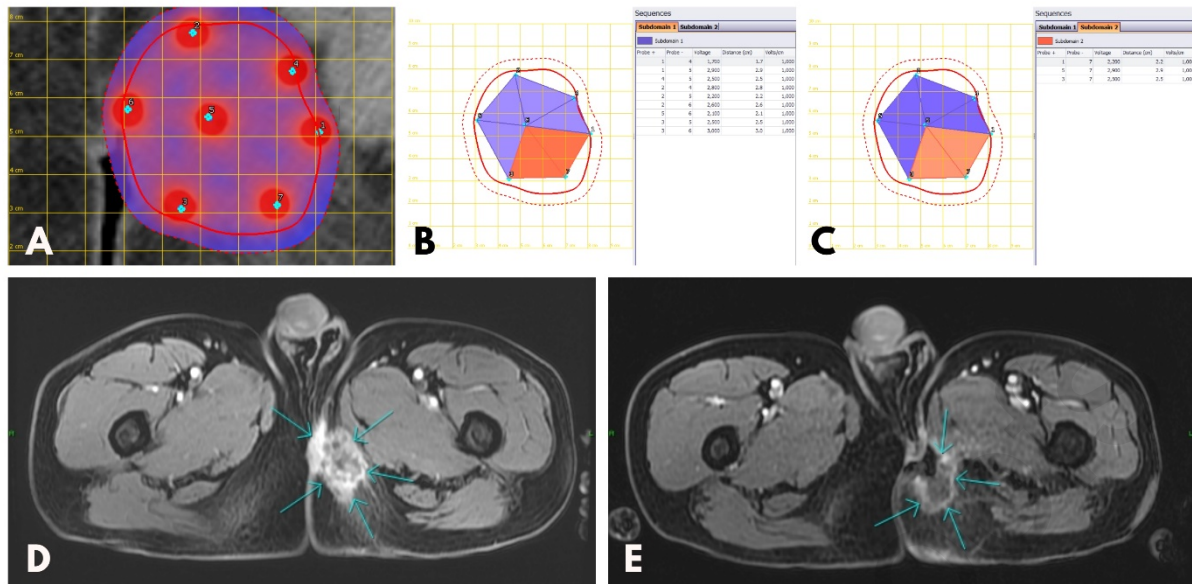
Treatment planning for VEG ECT for T4N1 epitheloid sarcoma of the left gluteal region. A: preECT electrode placement planning through Pulsar software. B, C: electrode placement and electrode repositioning with section (subdomain) 1 (purple) and -2 (orange) for sufficient current coverage and safety zones (red lines). D, E: MRI- axial T1-weighted 3D measuring after Gadolinium. D: preECT- venous phase image- arrows showing inhomogenous contrast enhancement at the sides of the tumor. E: postECT- central tumor necrosis, with only marginal enhancement and wide tissue absence on the medial side of the gluteal muscle. [preECT tumor volume: 249.11 cm^3 vs postECT tumor volume: 61.1 cm^3 ; volume change: -75.48%]. VEG: variable electrode geometry; ECT: electrochemotherapy; MRI: magnetic resonance imaging
